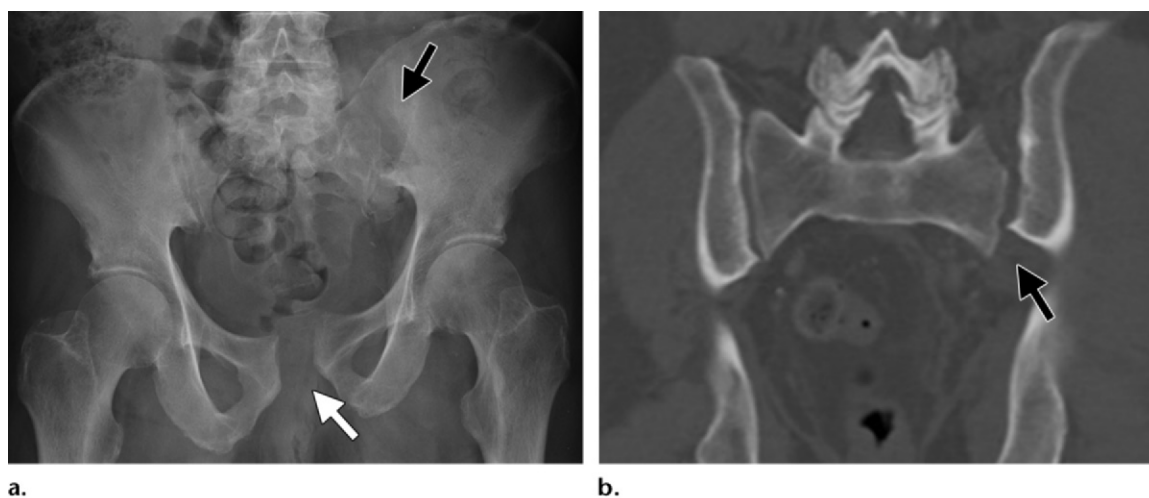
Vertical shear in an 80-year-old woman who sustained a pelvic injury after a mechanical fall. (a) AP radiograph of the pelvis shows widening of the pubic symphysis (white arrow) and left SI joint (black arrow), with relative cranial displacement of the left hemipelvis, findings consistent with a vertical shear injury. (b) Coronal CT image shows the vertical displacement (arrow). (c) Postoperative AP radiograph shows anterior stabilization of the pubic symphysis and posterior ring stabilization of the left SI joint.
